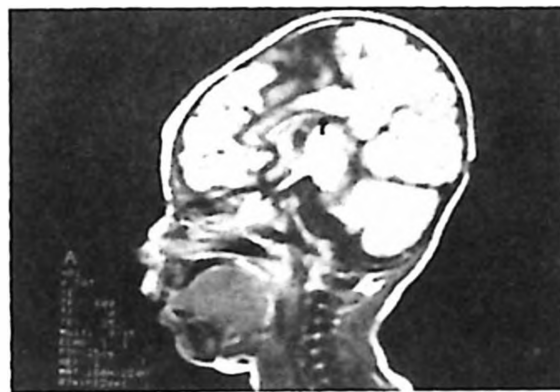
T1-weighted sagittal image shows severe callosal thinning anteriorly and its absence posteriorly (hypogenesis). Note that the cingulate gyrus overlying the thin callosal structure, falsely appears as a normal corpus callosum.
